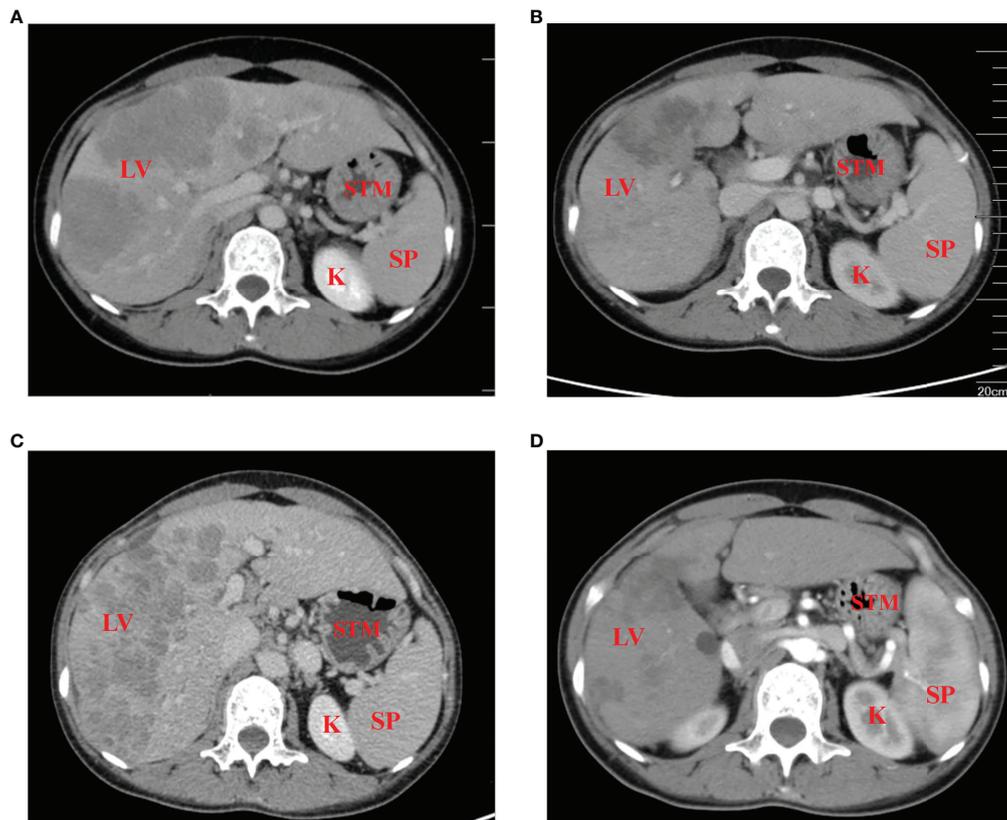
Contrast-enhanced CT scans of the patient (A) prior to, and (B) 5 months after the initiation of therapy. (C) At 6 months post-diagnosis, the curative effect was evaluated as progressive disease, with no effect of third-line therapy of Tislelizumab combined with Apatinib. (D) The disease returned to partial remission after treatment with the fourth-line treatment. LV, liver; STM, stomach; SP, spleen; K, kidney.
